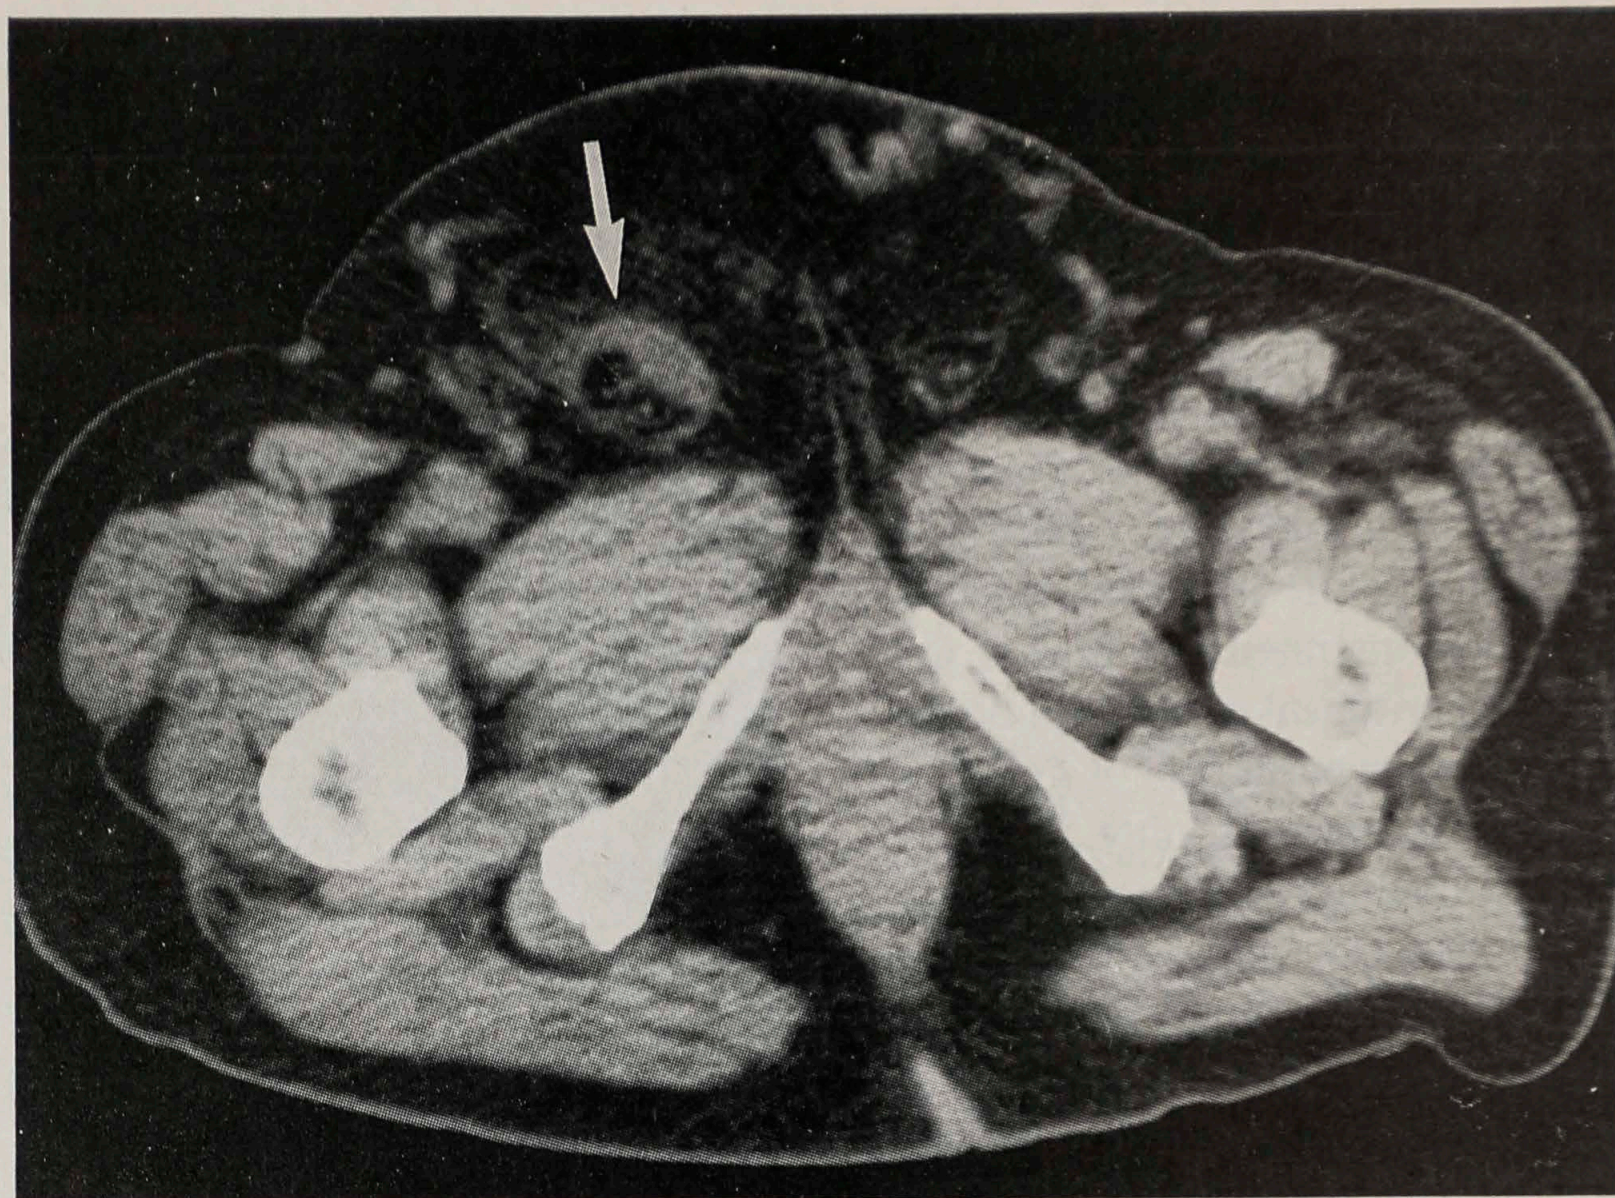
Case 2. Computed tomography scan indicates mass in right inguinal canal (arrow).
